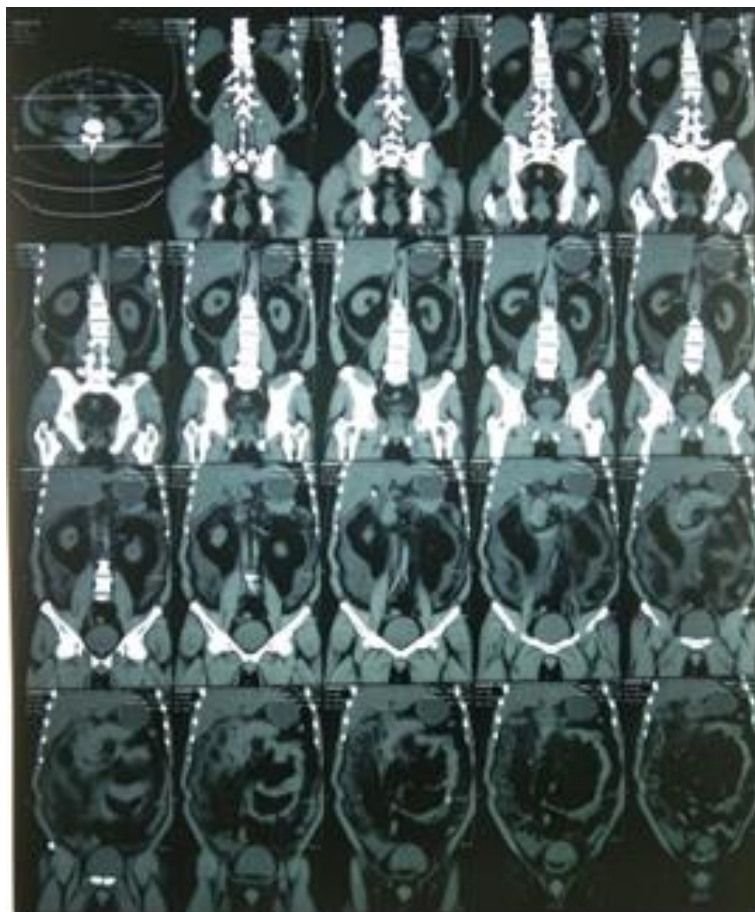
Abdominal CT Scan Results
